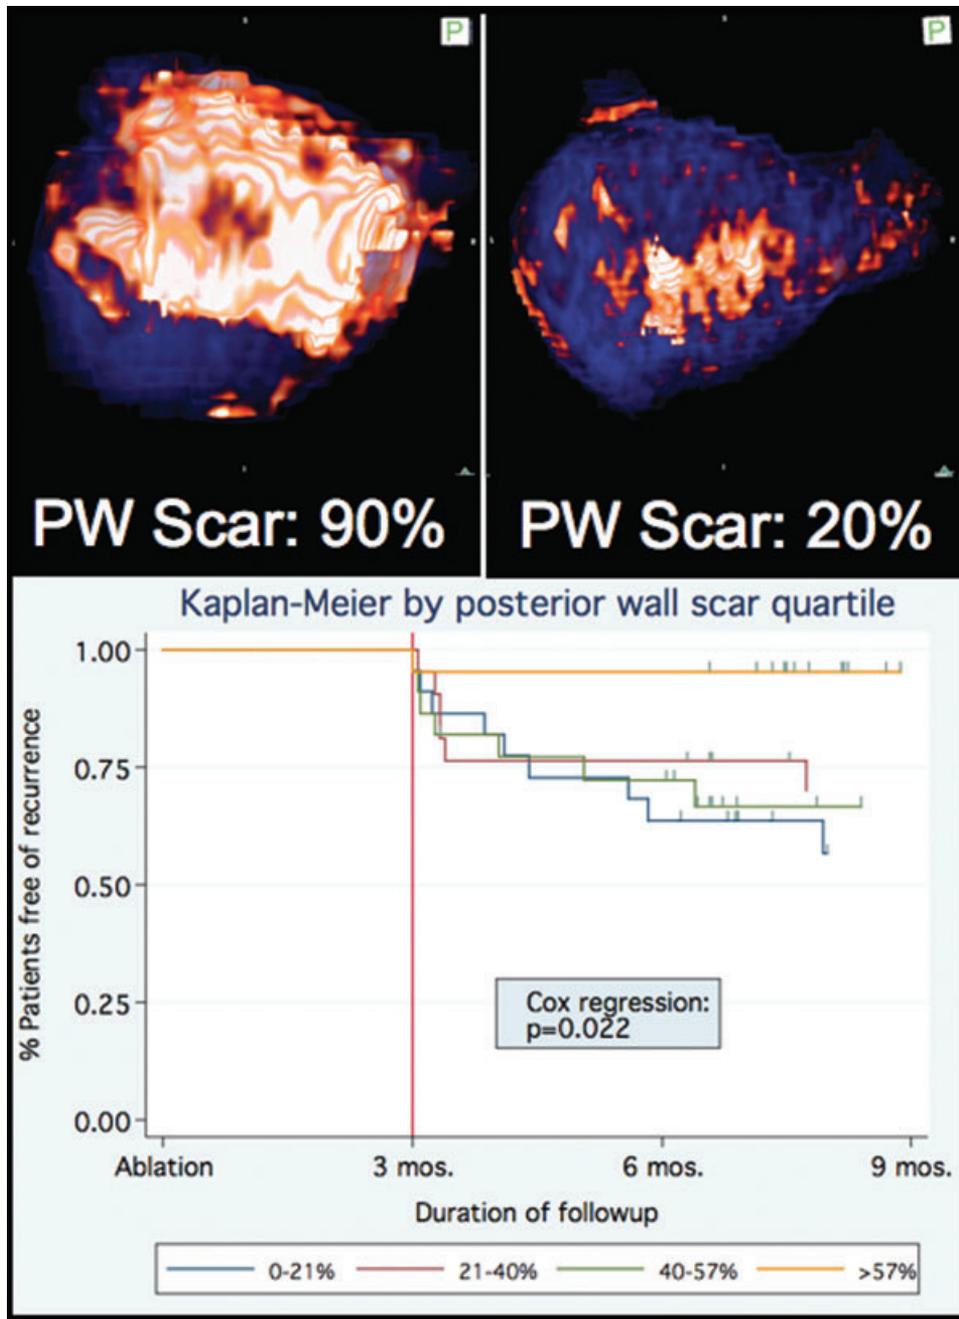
Posterior wall scar quantitation. These example posteroanterior (PA) projections of 3D reconstructions of DE-MR images of the left atrium allow quantitation of scar distribution within the posterior wall.
